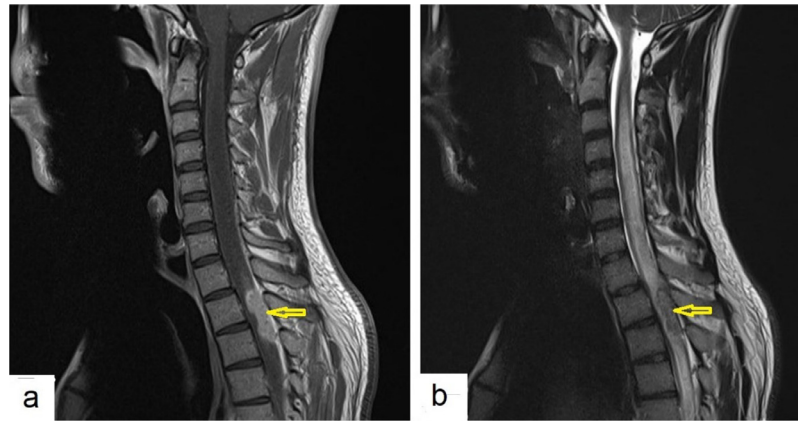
Selected sagittal images of magnetic resonance imaging of a 30-year-old male patient (A) T1-weighted image with IV contrast of the cervical and thoracic spine demonstrated a medium size oblong shape intramedullary lesion in the posterior aspect of the thoracic cord spanning <2 vertebral bodies (arrow), with cord expansion at T2-T3 level with avid enhancement with no epidural component or adjacent leptomeningeal enhancement, and (B) sagittal T2-weighted image of the cervical and thoracic spine shows a medium size oblong shape heterogeneously low T2 signal intensity intramedullary lesion in the posterior aspect of the thoracic cord spanning <2 vertebral bodies, (arrow) with cord expansion at T2-T3 level. There is a large surrounding high signal intensity of the cord reach to cervical region upward to C2 level and distal thoracic cord concerning with cord edema.
